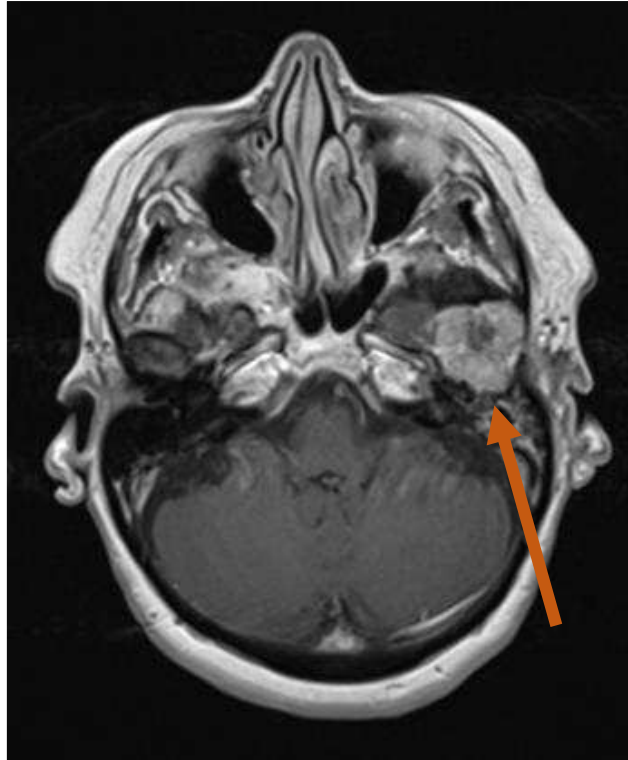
Axial view of T1 weighted MRI with tumour evident in the left TMJ (arrow)
